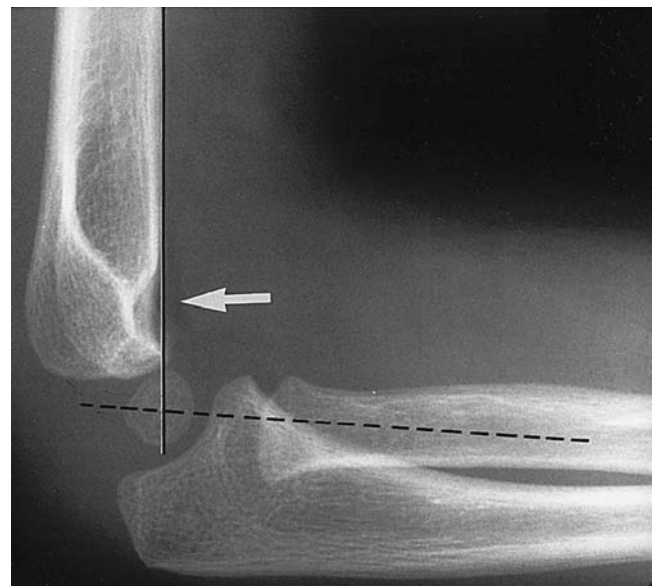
Normal lateral radiograph of the elbow of a 2-year-old child. The anterior fat pad is readily seen (*arrow*); the posterior fat pad is not visible. A line drawn along the anterior cortex of the humerus intersects the capitellum in its middle third (*solid line*). A line drawn along the axis of the radius also passes through the center of the capitellum (*dashed line*).
